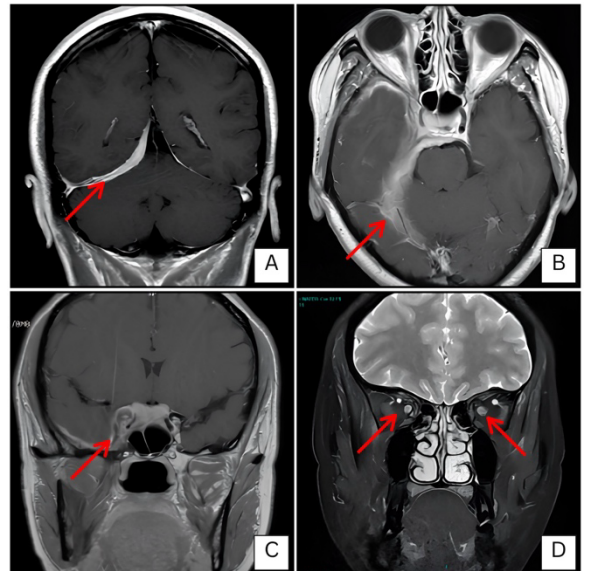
MRI done 10/24/25. Arrows show the areas of leptomeningeal enhancement, evident on T1 and T2-weighted images with contrast (a, b arrows). The right cavernous sinus (c, arrow) and the perineurium of both optic nerves show contrast enhancement (d, arrows).
